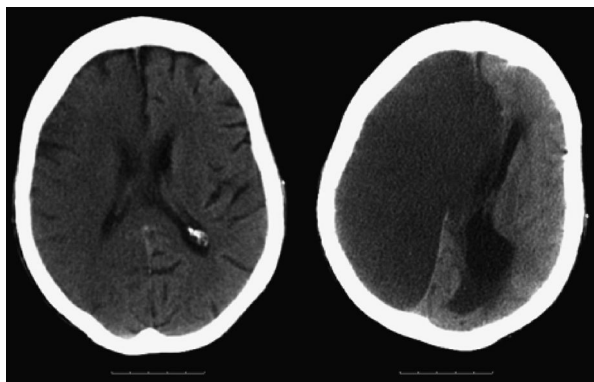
Pair of CT images. The slice on the left shows subtle signs of an early large right carotid territory infarct. After 3 days, the infarct has swollen massively and is compressing the left hemisphere with midline shift and hydrocephalus. © Anthony Pereira.
